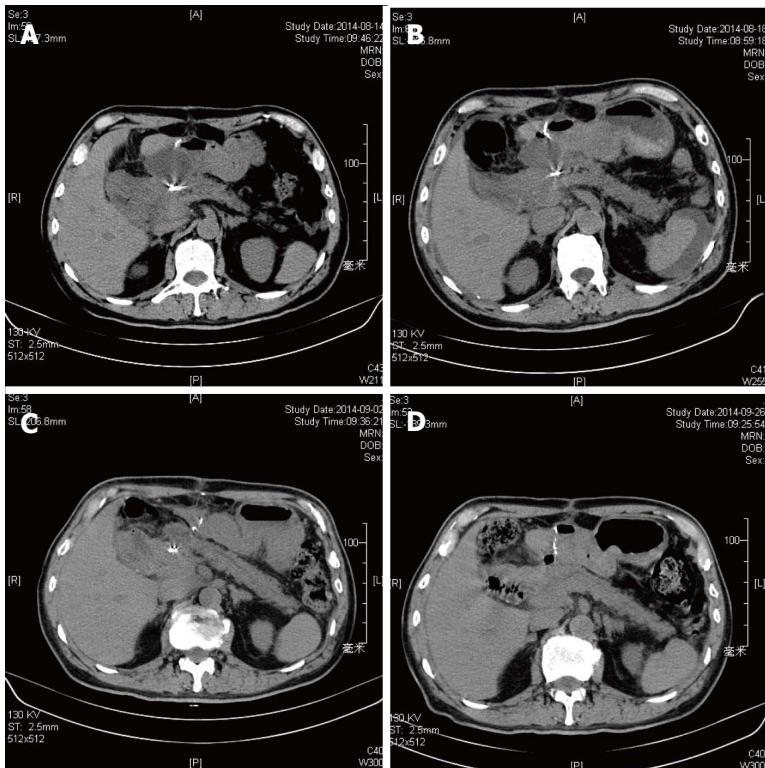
Re-intervention of pancreatic fluid collection drainage. A: Computed tomography (CT) scan before procedure; B: CT scan after first procedure (72 h); C: CT scan after re-intervention (72 h); D: CT scan after procedure (1 mo).
